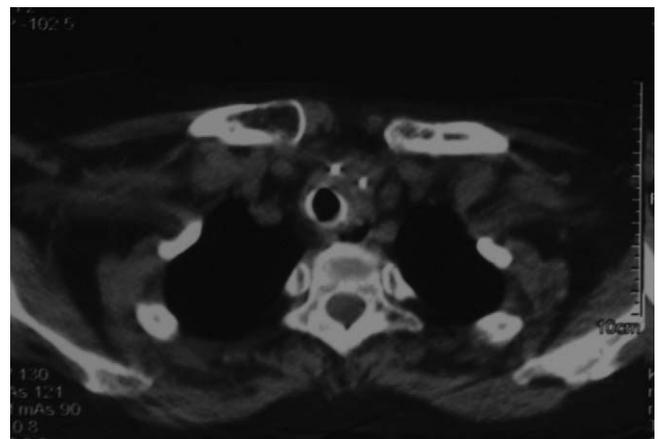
CT image obtained after balloon resection and silicone stent placement.
